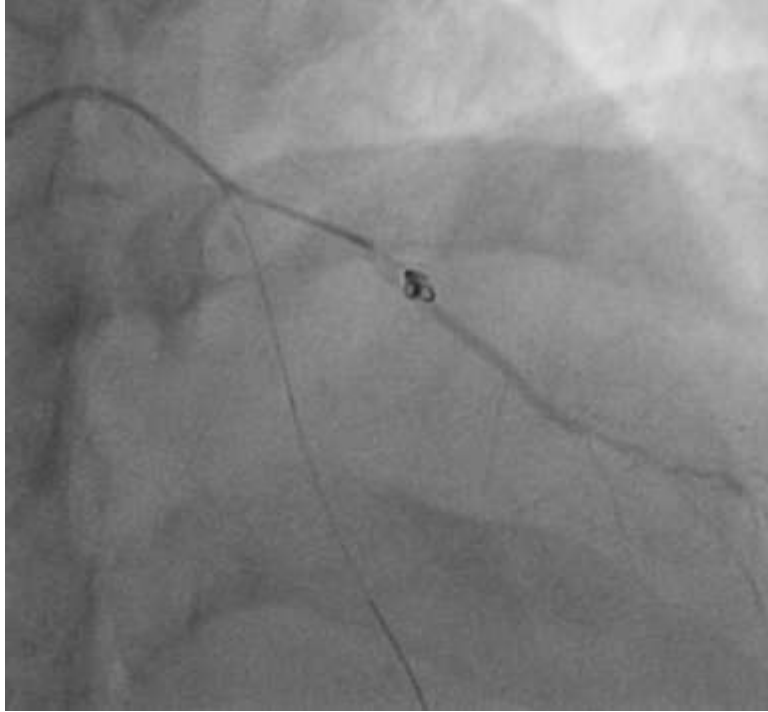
Final angiogram post coil embolization showing complete sealing of the perforation with no residual leak. PCI to the LAD was deferred to avoid further procedural risk. The patient remained stable during hospitalization, and serial echocardiograms showed no delayed pericardial effusion. He was discharged 48 hours later in good condition.
